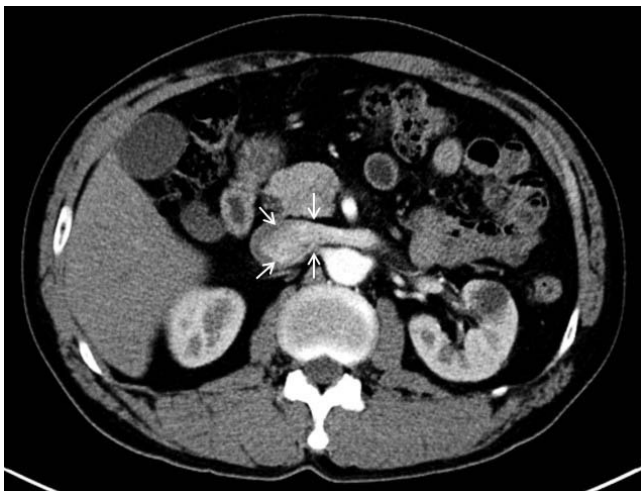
Normal left renal vein plug-flow pattern. Contrast-enhanced CT image of a 56-year-old male in the early arterial phase. Normal contrast medium flow from the left renal vein is observed to fill the entire inferior vena cava lumen with a smooth margin in a plug-flow pattern (arrows).
